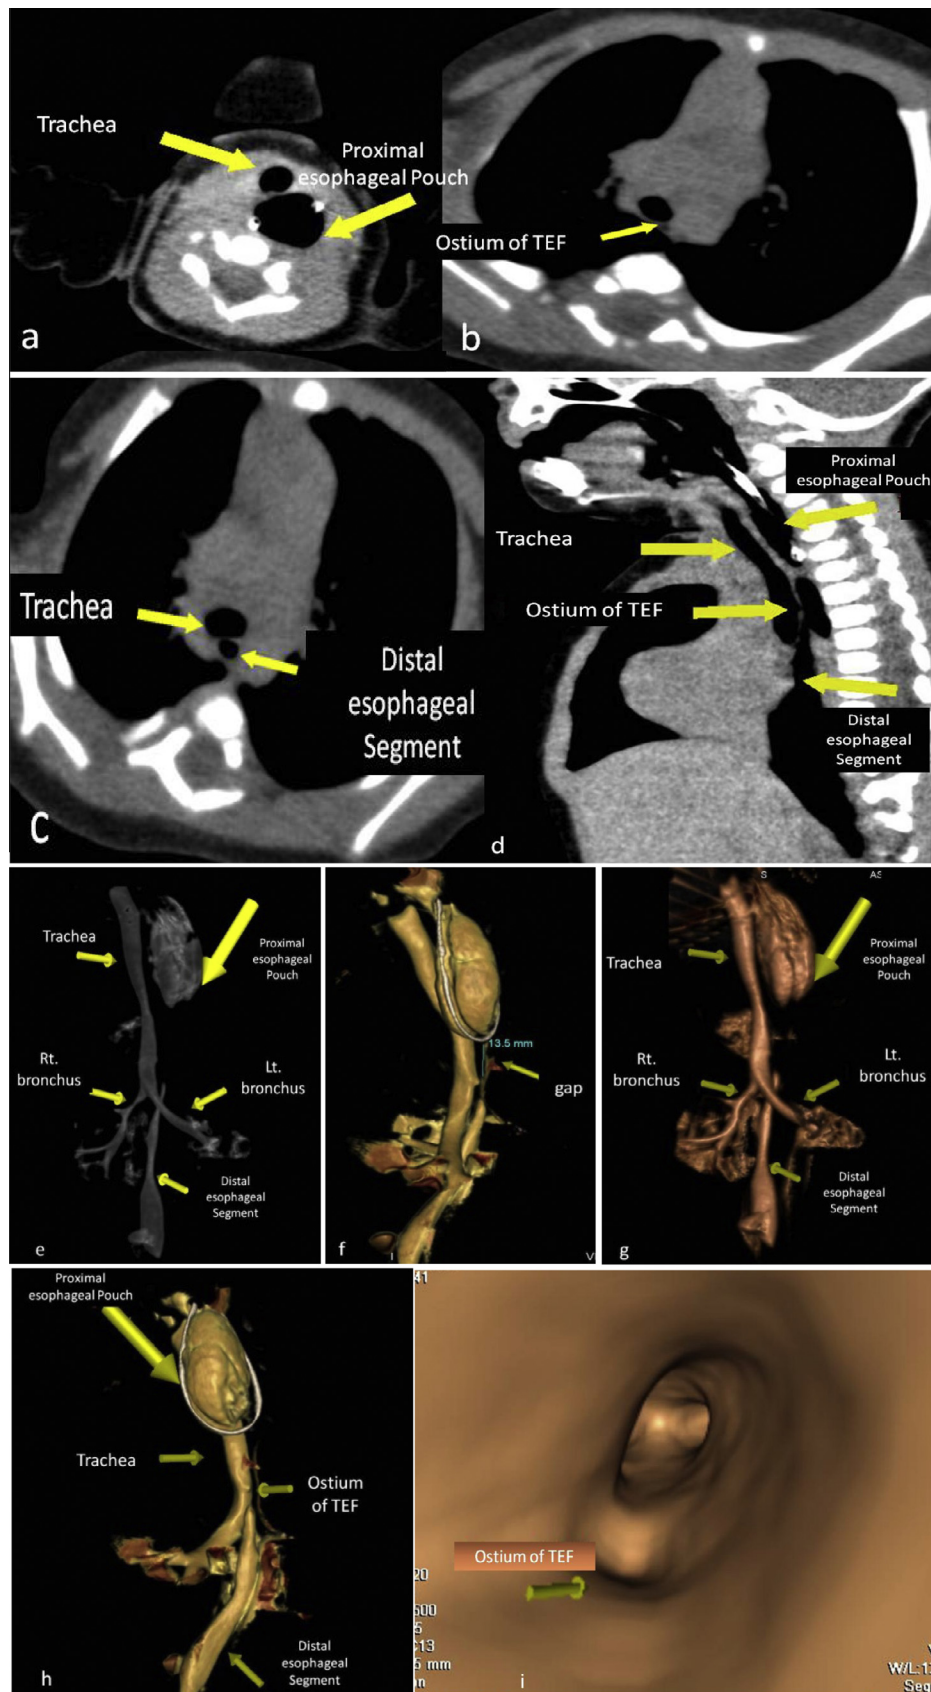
(a–c) Axial images, (d) sagittal image, (e–h) 3D TLVR revealed TEF type with proximal esophageal pouch, gap (esophagus atresia) 13.5 mm in length and distal esophagus opening with posterior aspect of distal trachea and (i) virtual CT tracheo-bronchoscope revealed orifice of TEF within the posterior aspect of distal trachea proximal to its bifurcation.
